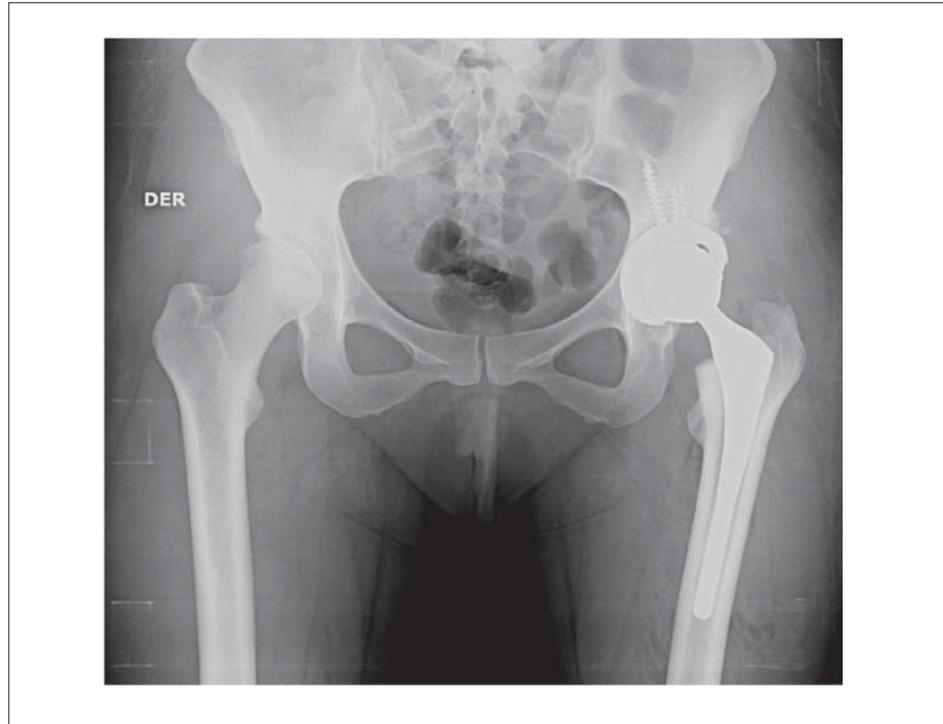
Postoperative pelvis X-ray after conversion to total hip arthroplasty of left hip
